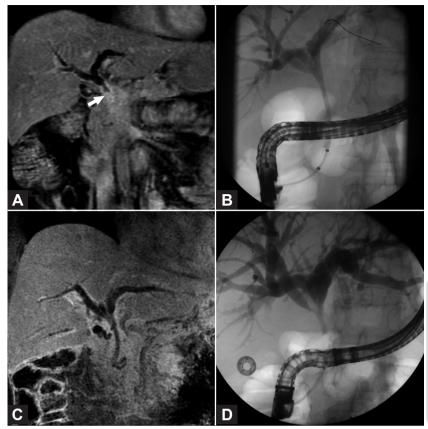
Photodynamic therapy (PDT) for a hilar cholangiocarcinoma. A) Magnetic resonance imaging (MRI) with gadolinium in the late phase showing hilar biliary stenosis (arrow). B) Endoscopic retrograde cholangiography (ERC) of the same patient before therapy. C) MRI after 9 months of the first session of PDT with reduction of the biliary obstruction. D) ERC aspect after 9 months of PDT. A second session of PDT was performed.
